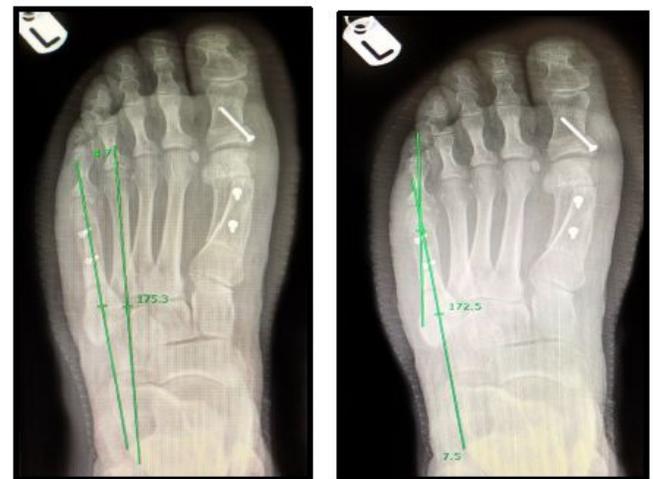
Image C, D: 2 weeks post-op non weightbearing radiograph of Tailor's bunion
